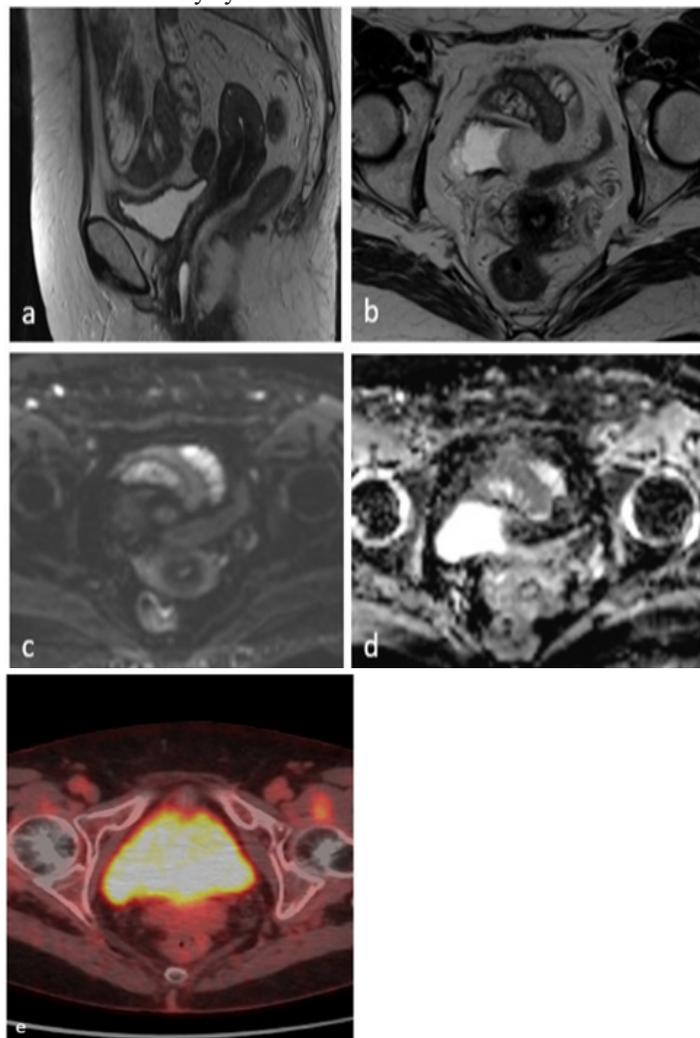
After three months of antibiotic therapy, a pelvic MRI was requested to evaluate the status of the cervical lesion (a-d): sagittal T2-weighted (a), axial T2-weighted (b) and diffusion sequences (c, d) show the complete resolution of the cervical mass. TEP-CT shows no cervical hypermetabolism (e).
